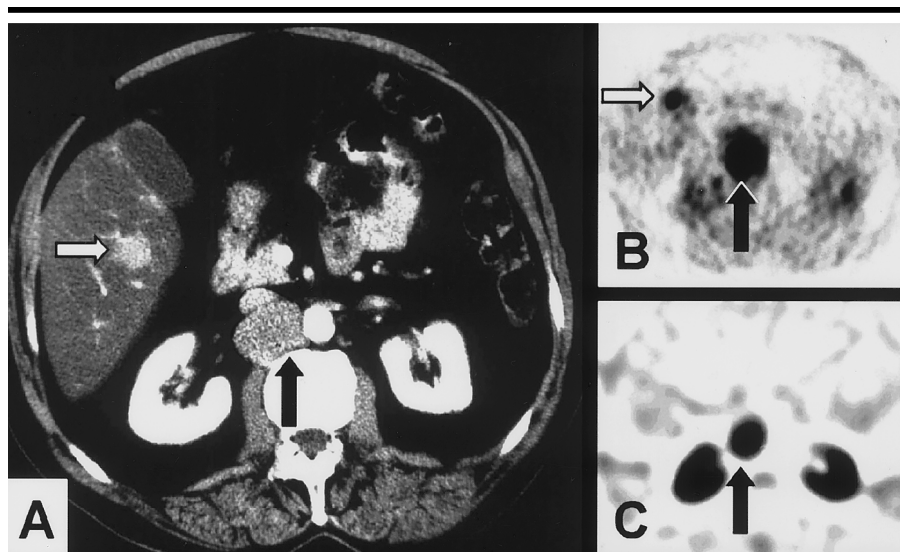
Ileal tumor with multiple metastases in a 61-year-old man. Whereas transverse CT (A) and transverse ^{18}F dopa PET (B) images both show a retroperitoneal lymph node metastasis (black arrows) and a hepatic metastasis (white arrows), the corresponding transverse somatostatin-receptor image obtained by means of SPECT (C) depicts only the lymph node metastasis (arrow). The hepatic metastasis apparently shows no receptor expression.
